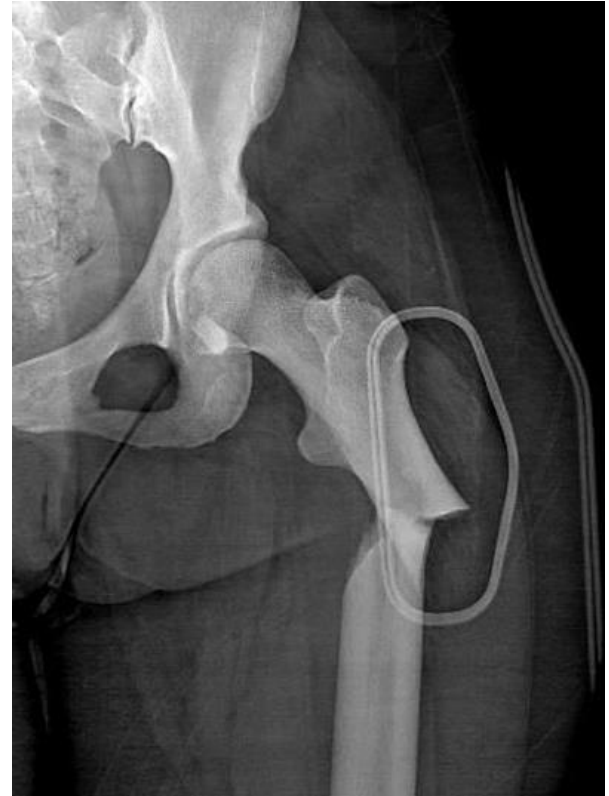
Anteroposterior x-ray of the patient demonstrating the transvers subtrochanteric fracture.
